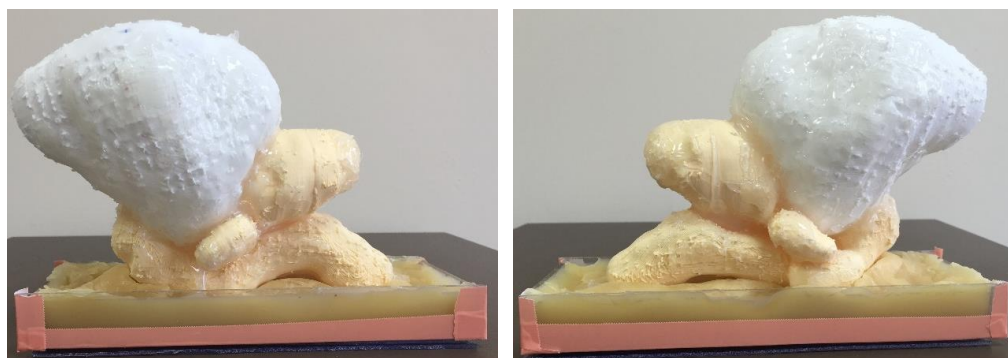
The patient-specific 3D printed plastic hollow organs, glued together as seen in the original patient CT scan. The lower part shown in the image is a stand made of tissue mimicking wax in order to keep the organs in the upright position.
